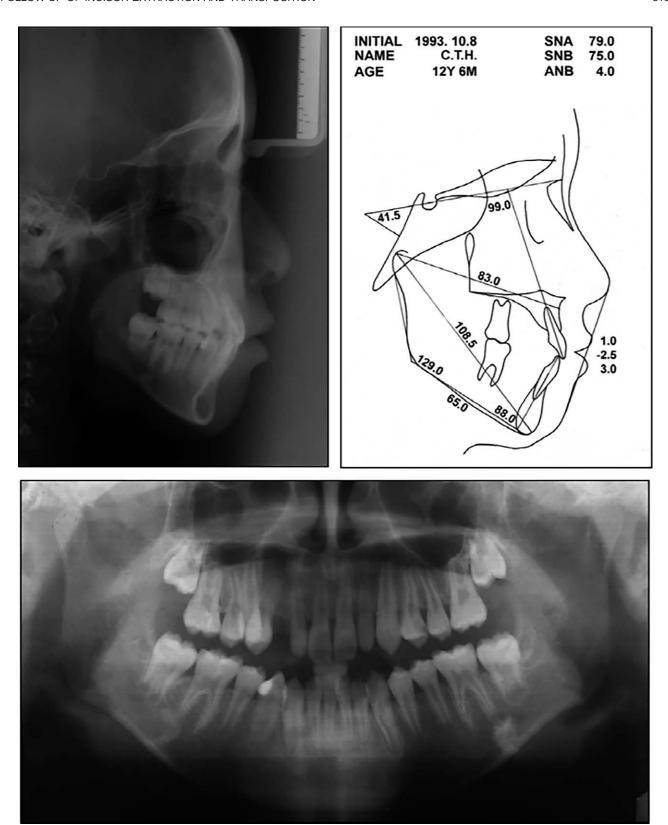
Pretreatment radiographs: lateral cephalogram, lateral cephalometric analysis, and panoramic radiograph.
